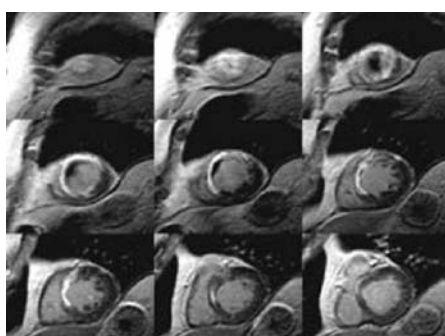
3D DE-MRI performed in a patient with a chronic infarction of the LAD distribution. This series of short axis images from apex to base was acquired in a single breathhold and has image quality nearly comparable to 2D images.
